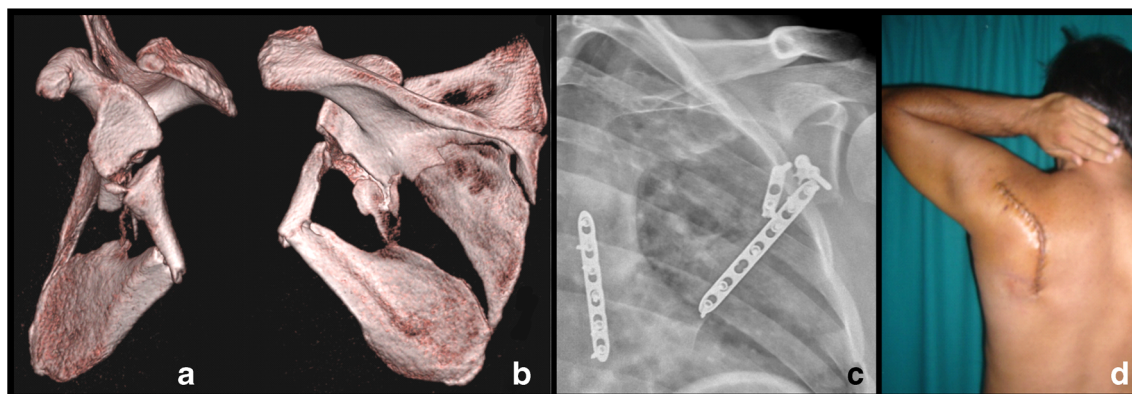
Inferior glenoid fracture and comminuted infraspinous fracture of scapular body (man, 53 year old). a + b – 3D CT reconstructions after injury; c – post-operative radiograph; d – shoulder function one week
